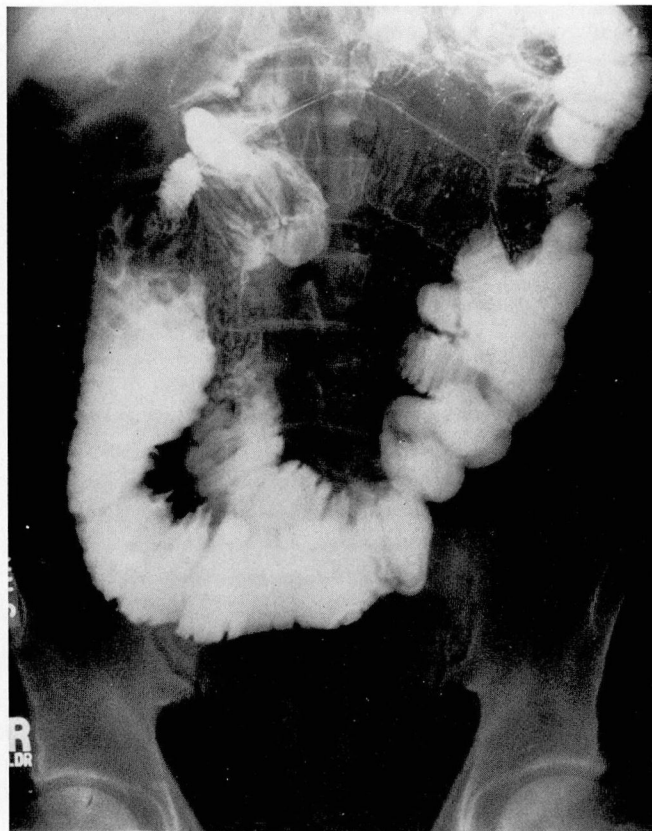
Case 4. Radiograph from repeat small bowel series showing marked dilatation of loops of the ileum and spiculated appearance of the mucosa.
